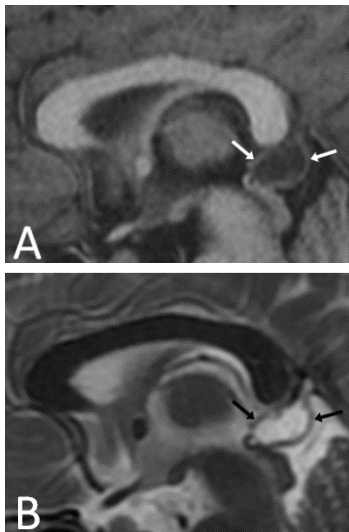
On MR imaging, a true pineal cyst (A) which appears hypointense in T1-weighted sagittal sequences and (B) hyperintense in T2-weighted sagittal sequences.
